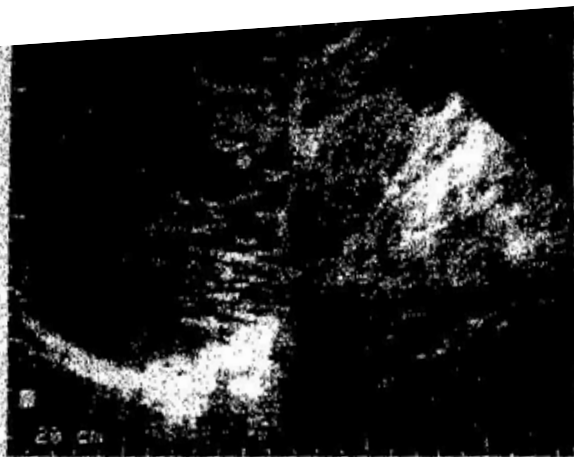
Longitudinal ultrasound scan through the right upper abdomen. Several cysts are identified between the liver (L) and the kidney (K).
